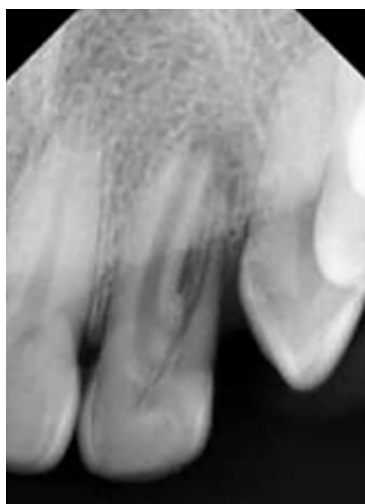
pre-operative radiograph of #22 showing two roots
